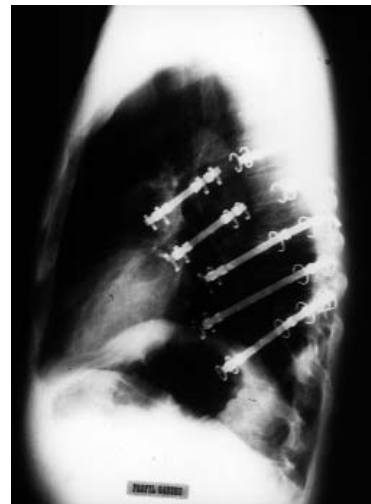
Post-operative profile X-ray
